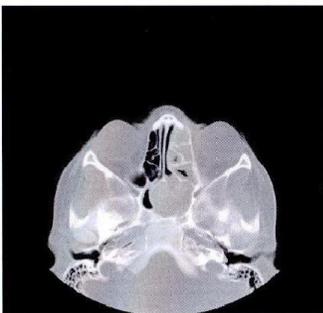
CT scan of the para nasal sinuses 8 months on itraconazole showed interval progression.
